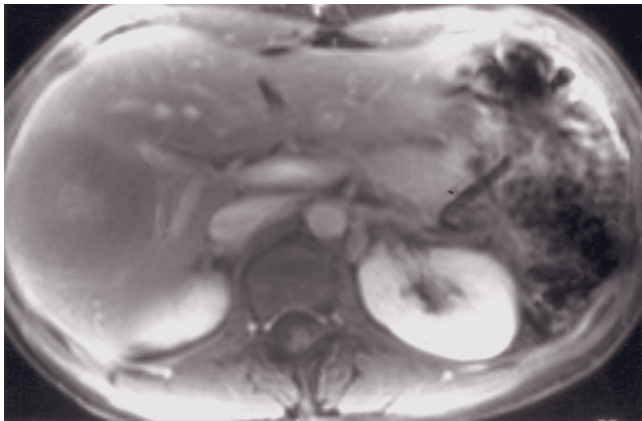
(*Continued*) T2-weighted fat-suppressed ETSE (d) and immediate (e) and 45-s (f) postgadolinium SGE images in a second patient before chemoembolization. This patient with recurrent fibrolamellar HCC possesses multiple liver lesions that are moderately high in signal intensity on T2-weighted images (arrow, d), show intense uniform enhancement immediately after gadolinium administration (arrow, e), and fade rapidly to isointensity with liver by 45 s (f). Immediate postgadolinium SGE image acquired 1 month after chemoembolization (g) shows complete lack of enhancement of the lesion, which now has polygonal angular margins (arrow, g), consistent with scarring.
